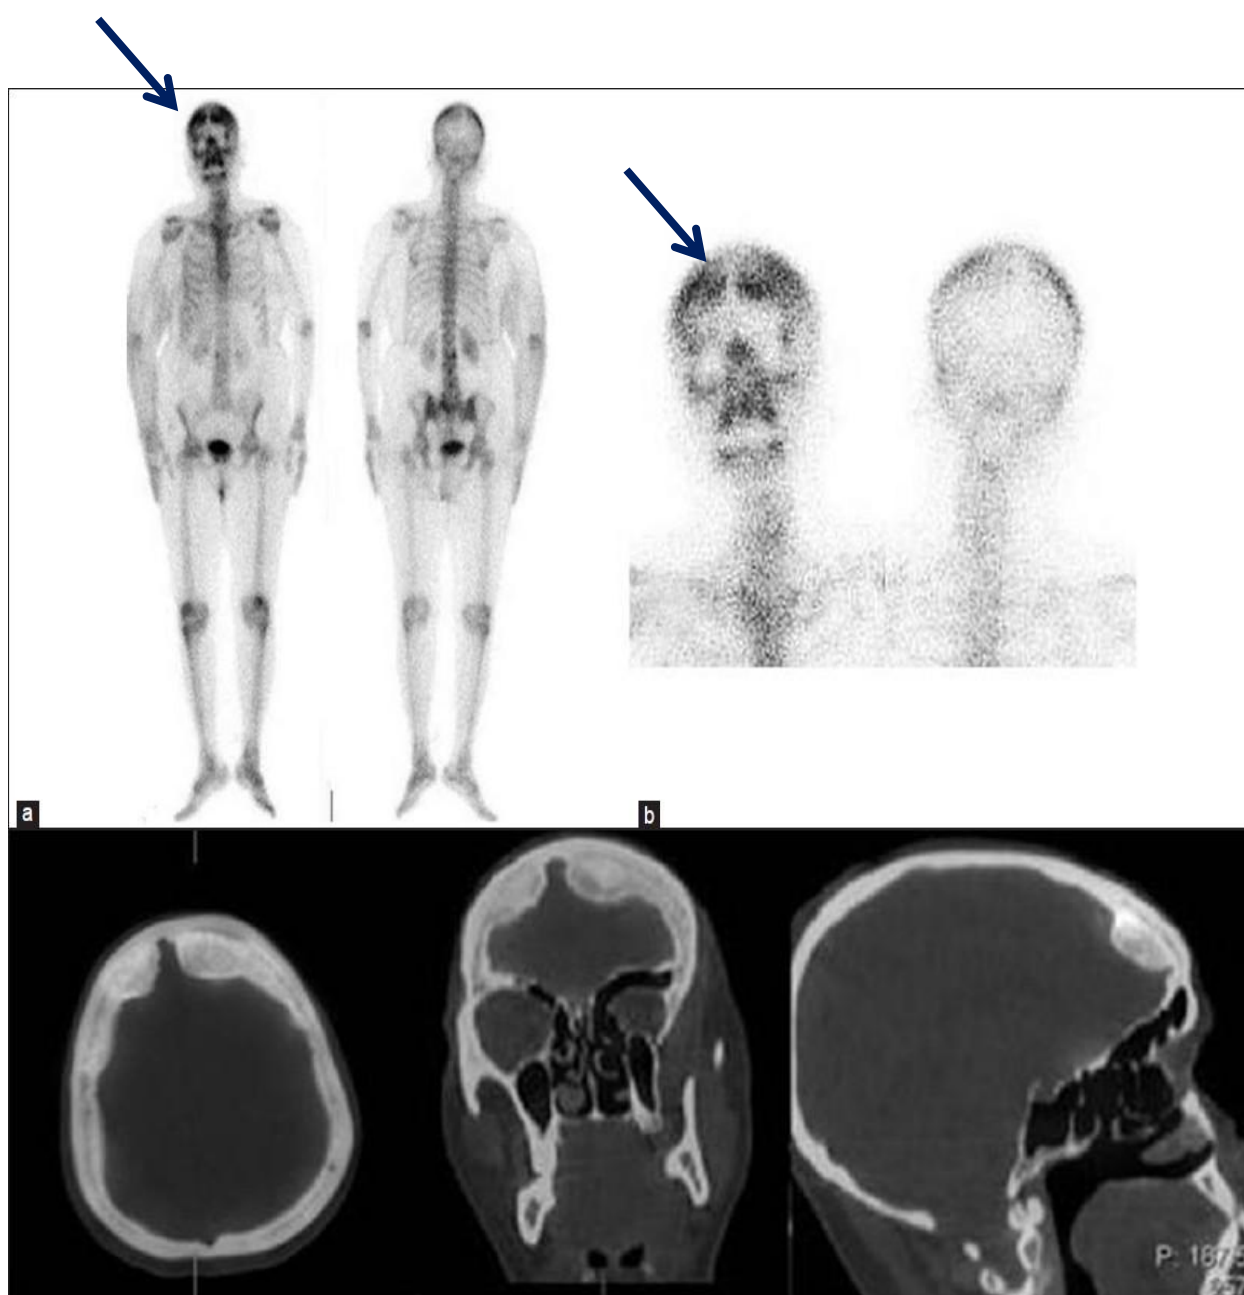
(Upper) Anterior and posterior whole body and spot view bone scan in a 60-year-old female with breast tumor, revealed heterogeneously increased tracer uptake (Arrows) involving bilateral frontal and parietal bones. The remaining skeleton showed normal tracer distribution. (Lower) CT of the cranium. Transaxial, Coronal and Sagittal images showed irregular thickening and nodularity of the inner table of bilateral frontal and parietal bones.
